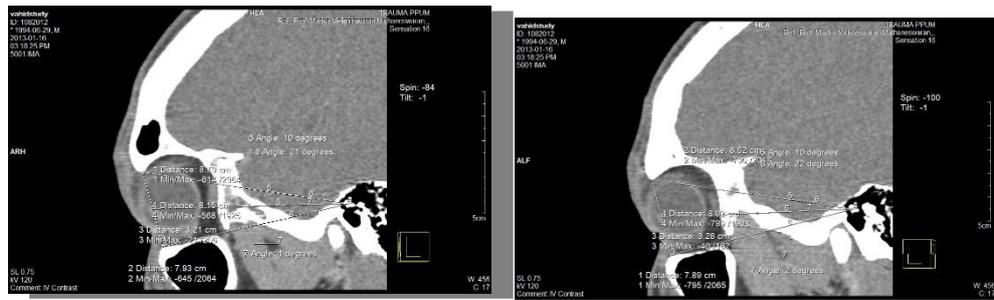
The left and right side of CT images.
